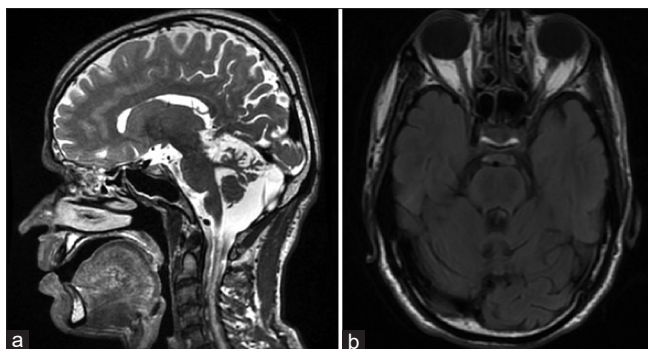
MRI brain T2 weighted image revealing superior cerebellar vermian atrophy (a) and linear “striped” hypointensities in pons (b)
